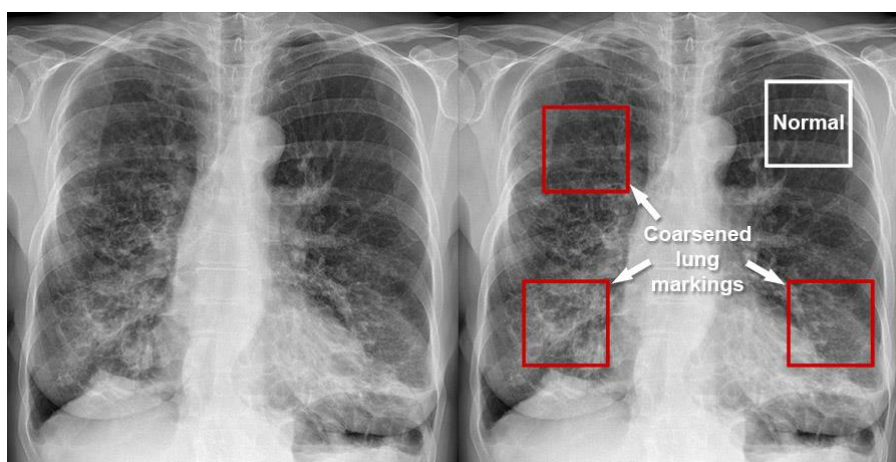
Chest X-ray- Pulmonary Bronchiectasis and Cystic Fibrosis
